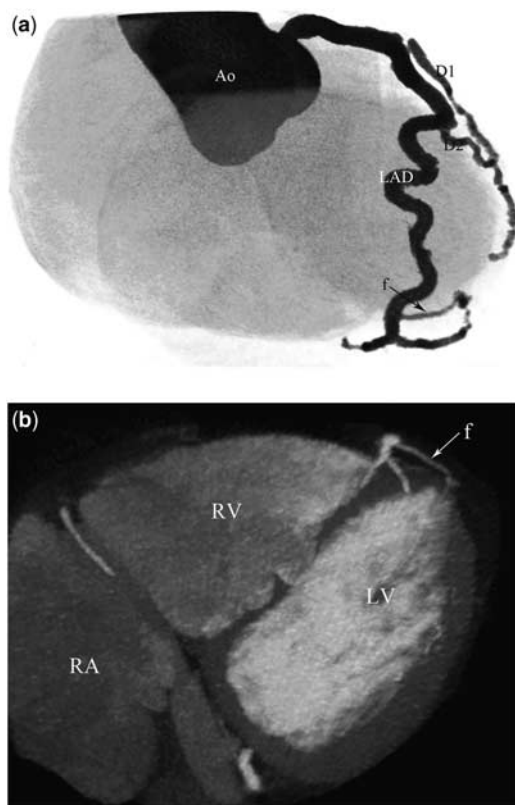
Coronary artery fistula in a 55-year-old woman. Volume-rendering (a) and coronal thin-slab maximum intensity projection (b) multidetector computed tomography images show a fistula (f) originating from the distal left anterior descending (LAD) artery and draining into the left ventricle (LV). Ao = aorta; D1 = first diagonal; D2 = second diagonal; RA = right atrium; RV = right ventricle.
